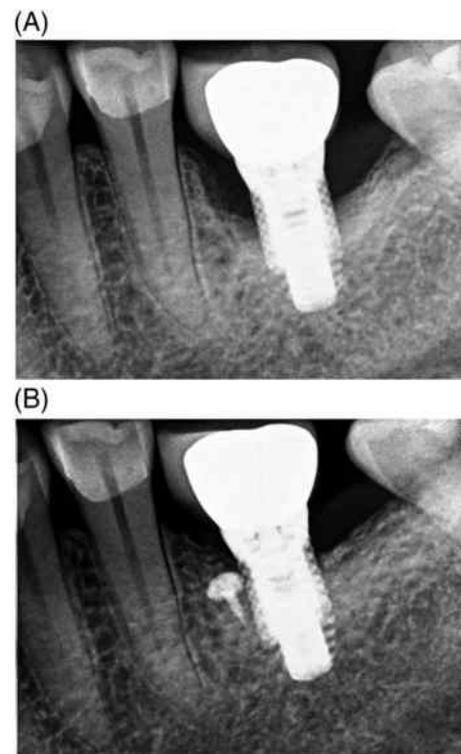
Periapical radiograph at baseline (A) and 1 year after surgery (B) showing a complete radiographic defect fill
